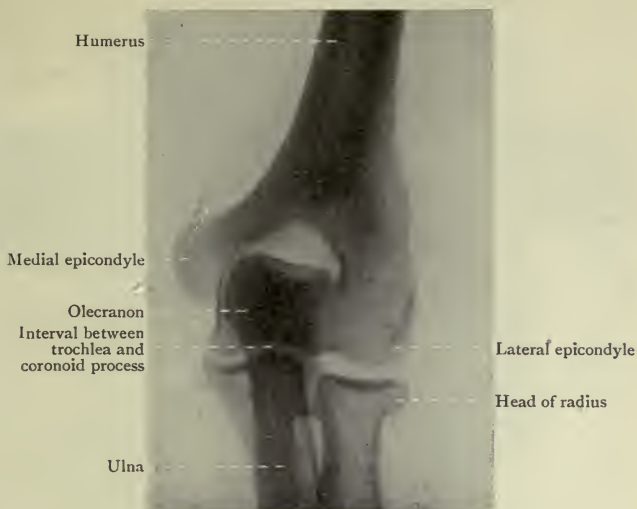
Antero-posterior Radiograph of extended Elbow Joint.
